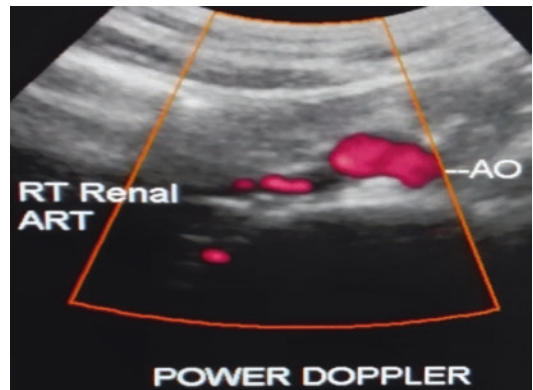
Origin of the right renal artery from the aorta in power Doppler mode
